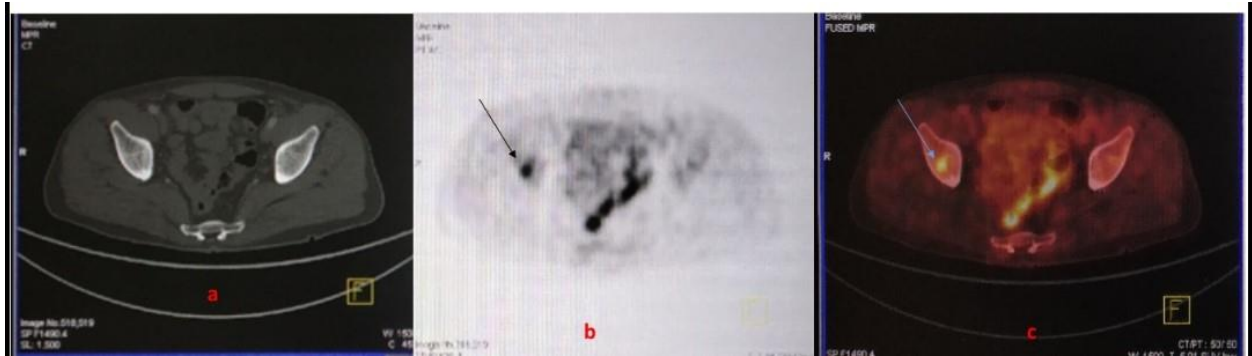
Unremarkable CT scan of lower abdomen and pelvis(a); Bone marrow involvement was considered negative in CT Compared to intense uptake in the pelvic bone on right side on PET and fused PET/CT (black arrow in b & blue arrow in c); Bone marrow involvement was considered positive in PET/CT.
